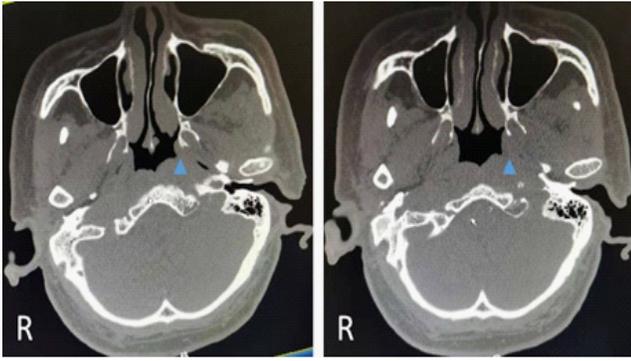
Representative coronal sections of a post antifungal treatment CT nasopharynx with contrast demonstrating the nasopharyngeal space occupying disappeared (blue triangle Δ).
